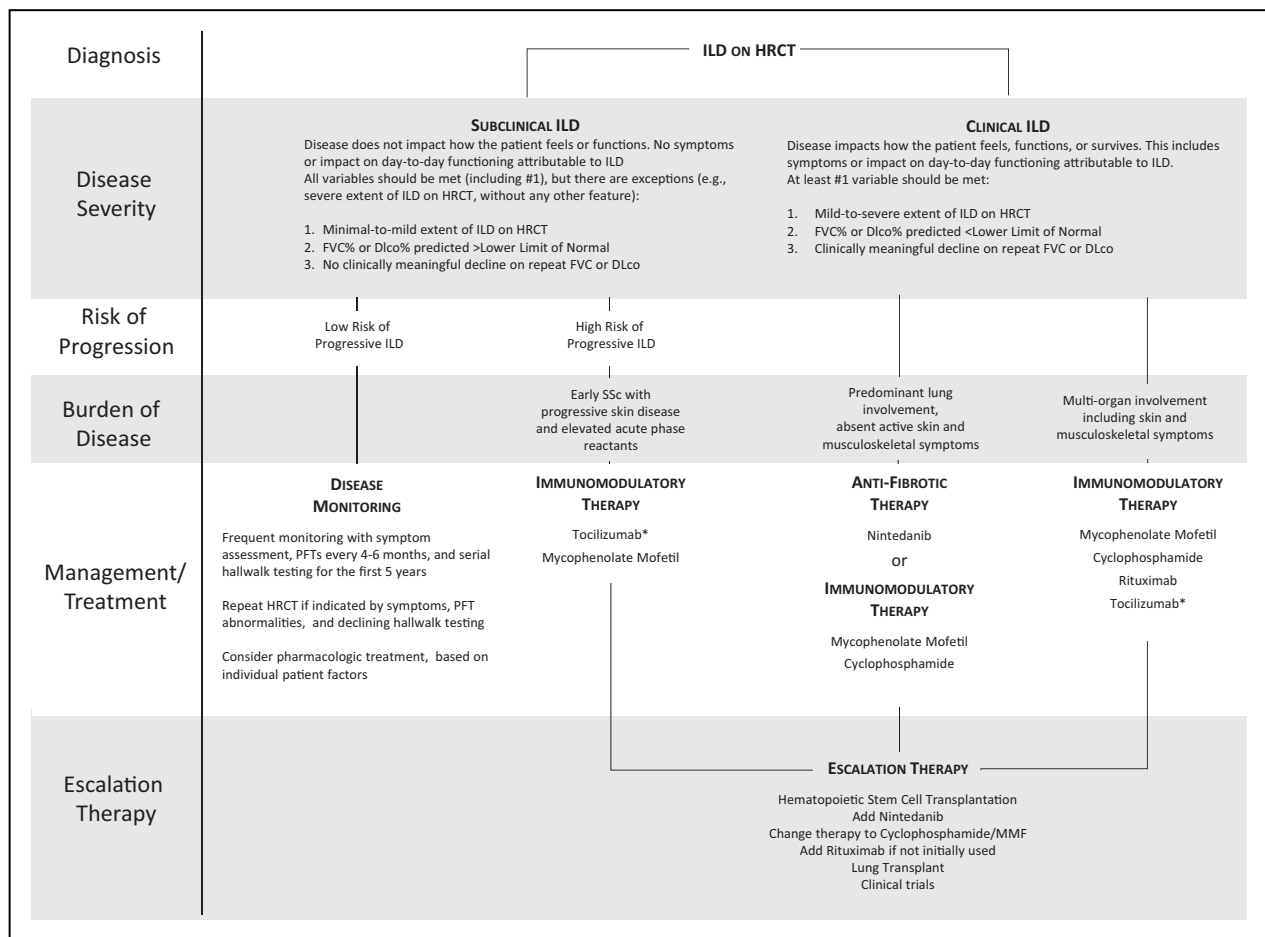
Treatment algorithm for systemic sclerosis-interstitial lung disease based on evidence-based recommendations and expert opinion/unpublished clinical experiences. Modified from the EULAR Online Course on Systemic Sclerosis, In depth discussion Module 9 (Management of SSc-ILD), updated 2020. *In those with early SSc with progressive skin and elevated acute phase reactants. Clinically meaningful change: if greater than one PFT available, a clinically meaningful decline is defined as FVC levels of more than 10% from baseline or decline in FVC greater than 5% to less than 10% and more than 15% relative decline in DLco. Testing acronyms: DLco%, diffusion capacity of carbon monoxide percentage predicted; FVC%, forced vital capacity percentage predicted; HRCT, high-resolution chest computerized tomography; PFT, pulmonary function testing. Disease acronyms: dcSSc, diffuse cutaneous systemic sclerosis; ILD, interstitial lung disease.
